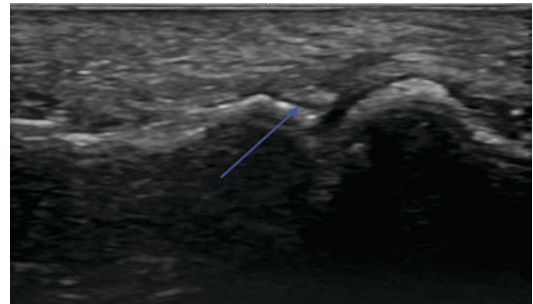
Fracture detection in the ultrasound
